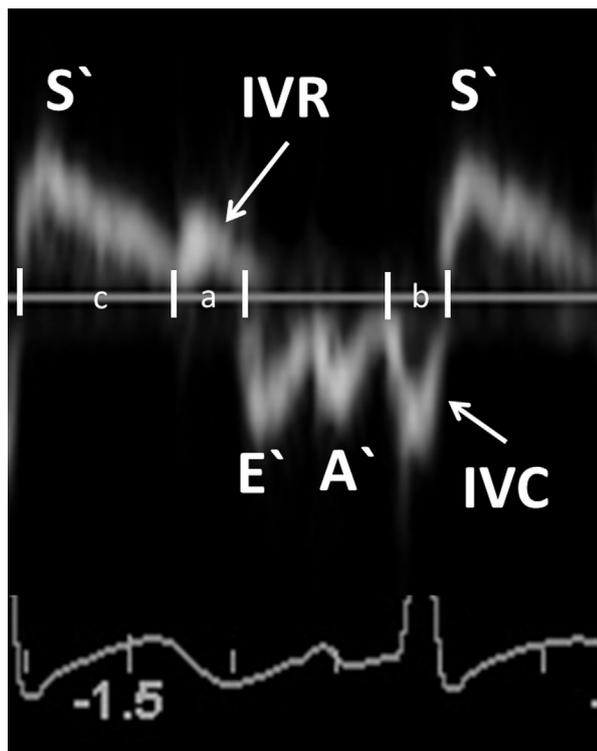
Tissue Doppler velocities of the LV in a preterm infant after PDA ligation. The different phases of the cardiac cycle are clearly identified. The systolic velocity (S') and early (E') and late (A') diastolic velocities can easily be measured. Isovolumic relaxation time (IVR and a) time and isovolumic contraction (IVC and b) time in addition to systolic time (c) can also be measured.
